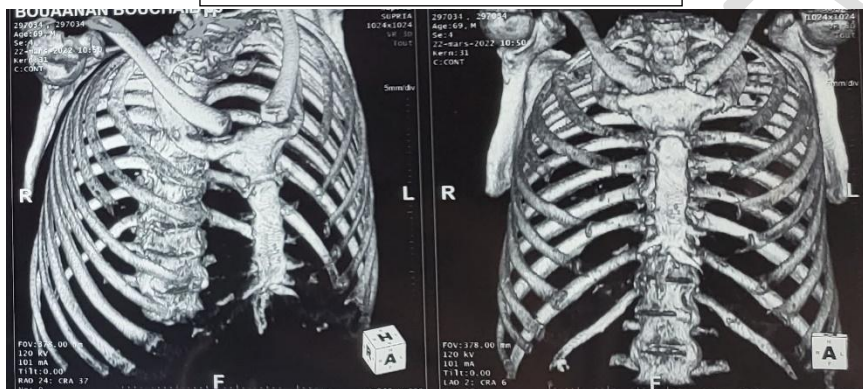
Bone window CT scan displaying lysis of the anterior arch of the 4th rib.
